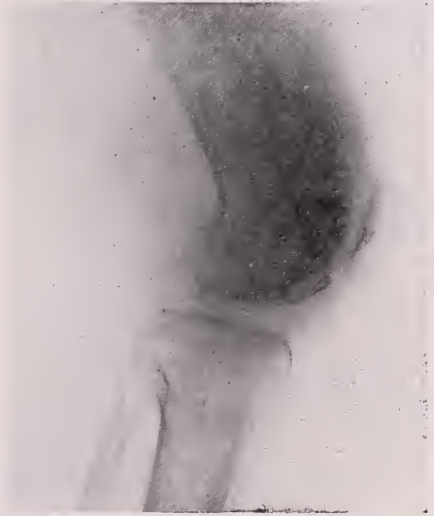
Case V. X-ray of left knee, lateral view, showing spotty areas of destruction through lower end of left femur.
